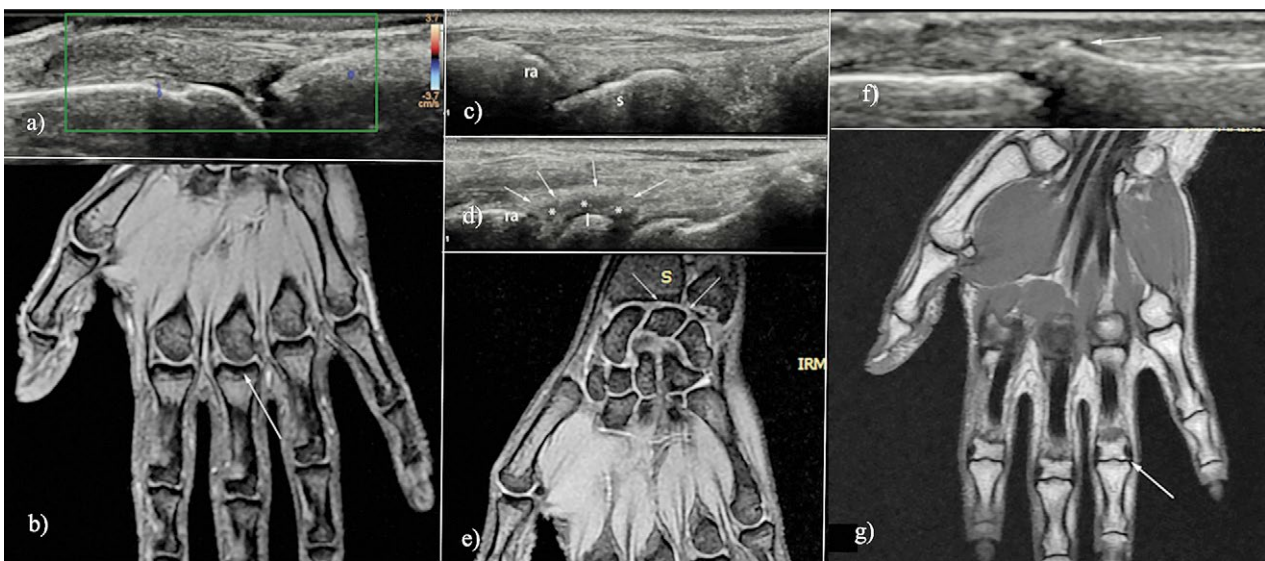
Female, 32 years old, 3rd MCP joint: a) longitudinal ultrasound with detection of a nutrient vessel; b) MRI, coronal plane, 2D MERGE sequence– no effusion inside the joint. Female, 26 years old, radiocarpal joint: c) longitudinal ultrasound, normal aspect between proximal radius (ra) and distal scaphoid bone (s); d) hypoechoic material distending the capsule (arrows) between proximal radius (ra) and distal lunate bone (l); e) MRI, coronal plane, 2D MERGE sequence, right hand – no pathological fluid at the radiocarpal joint, especially at lunate bone level (arrows). Female 32 years old, PIP joint: f) longitudinal ultrasound showing the sharp bony cortex- small osteophyte (arrow); g) MRI, coronal plane, T1 sequence - small osteophyte (arrow).
